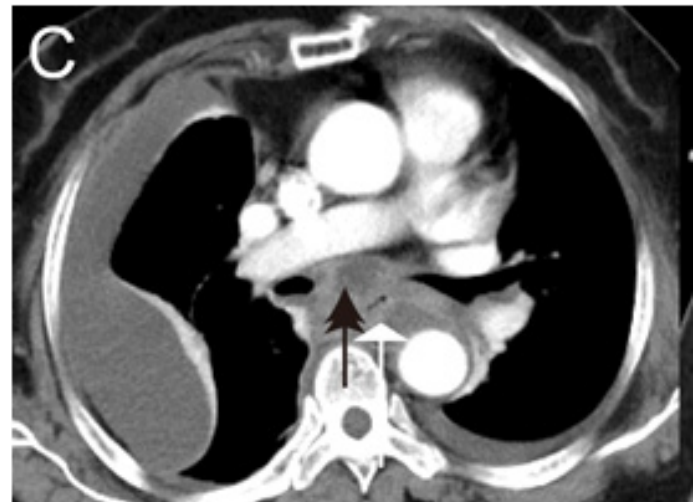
On third day of hospitalization, the enhanced CT cross-sectional image shows that the low-density area pointed by the black arrow is the formation of small abscesses beside the esophagus in the mediastinum and the white arrow points to the esophagus.
